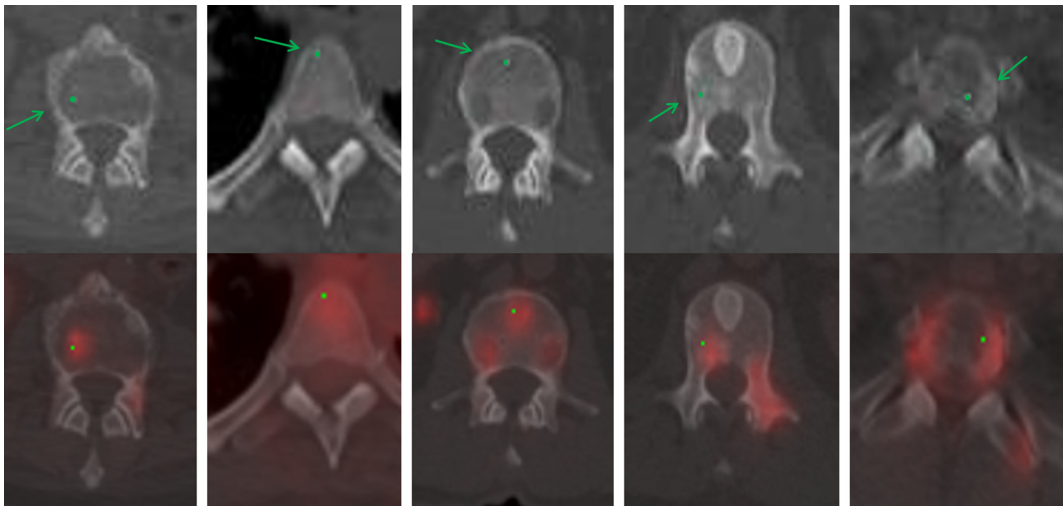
Lesions detected on PET/CT synthesis but not on CT alone. Green arrows point to lesions with green dots marking the center of the lesions. First row: CT and second row: PET/CT fusion.
